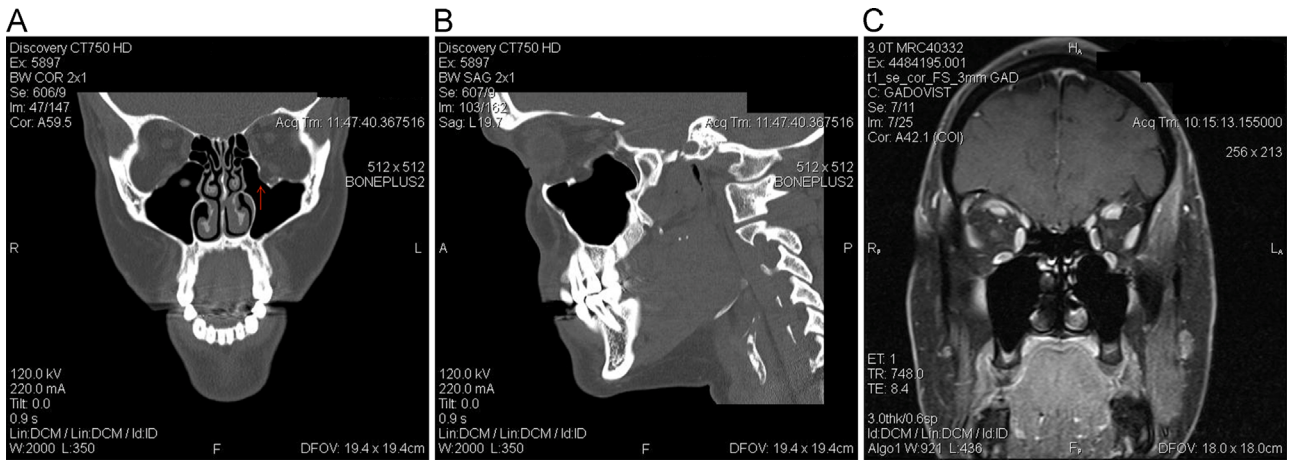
(A–C) Computed tomography coronal and sagittal views, and magnetic resonance imaging coronal view of orbits. Site of fracture is shown (arrow) with entrapment of inferior rectus and soft tissue on magnetic resonance imaging.
